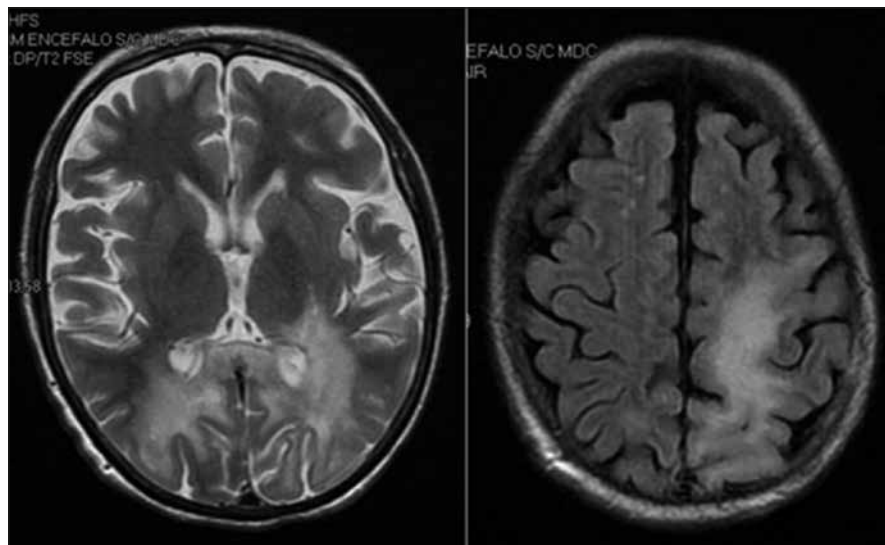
Brain Magnetic Resonance Imaging. Axial T2-weighted sequence (left) and axial fluid-attenuated inversion recovery (FLAIR, right). Typical progressive multifocal leukoencephalopathy-associated lesions are seen in parietal-occipital lobes and corpus callosum. The lesions were hyper intense on T2/FLAIR sequences and did not enhance with contrast.
